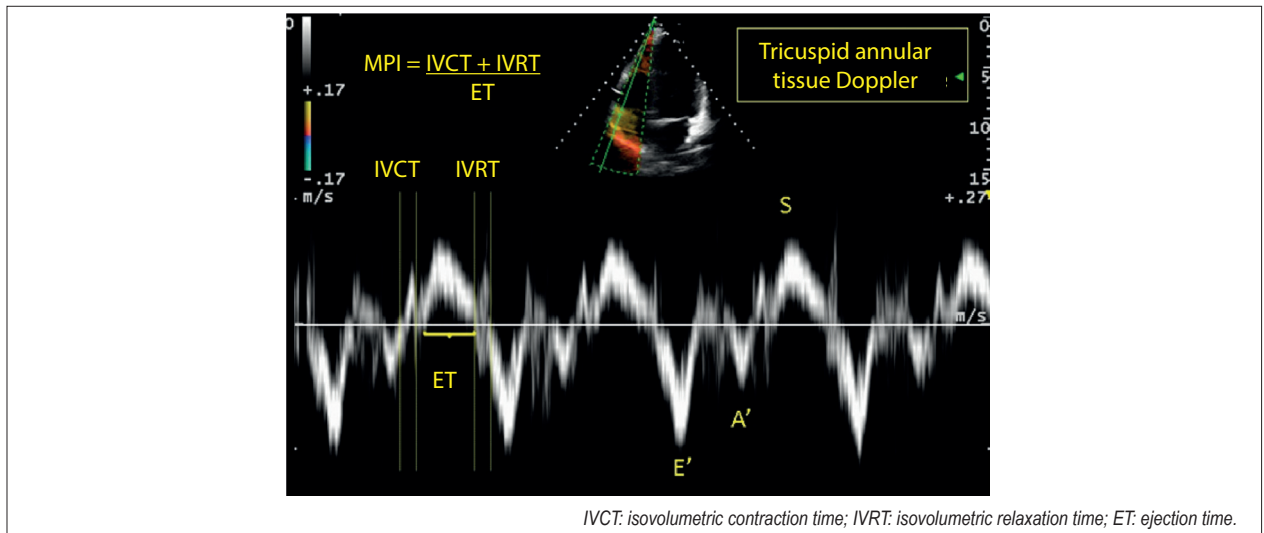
RV myocardial performance index (MPI) obtained by tissue Doppler.
